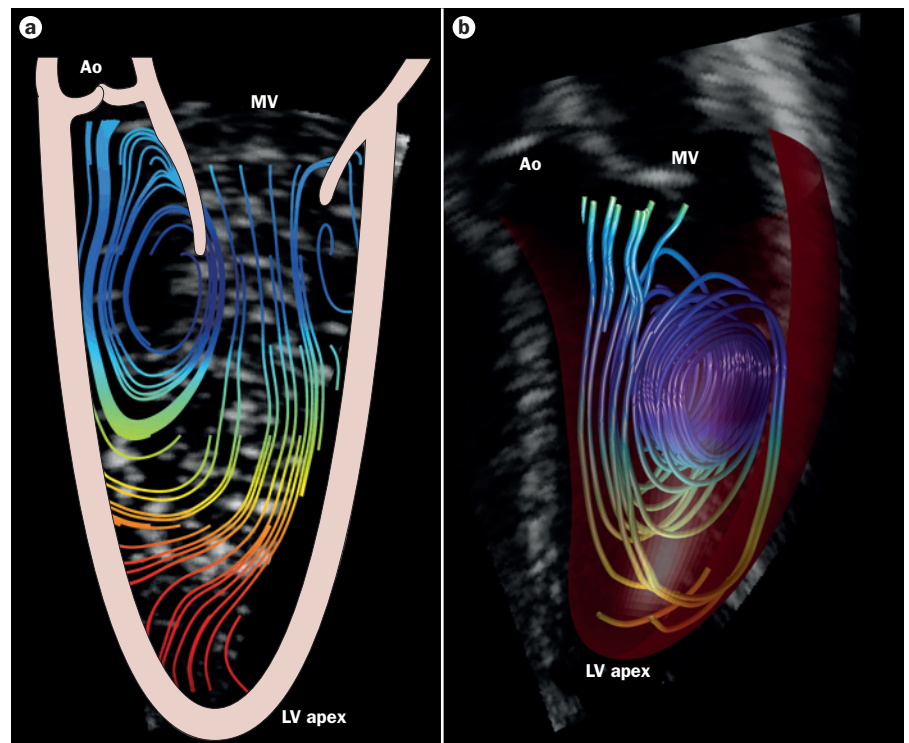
Echocardiographic recordings of intraventricular swirling flow in healthy individuals. a | Streamlines during late diastolic filling. The vortex is visible behind the anterior mitral leaflet. b | 3D streamlines reconstructed from multiplane acquisition at the onset of systole. The streamlines spiral out from the vortex and are directed towards the outflow tract. In both images, pressure gradient is directed from apex to the base (in colour scale from red to blue). Minimal pressure is found at the centre of the vortex for centrifugal effect. Abbreviations: Ao, aorta; LV, left ventricular; MV, mitral valve.
